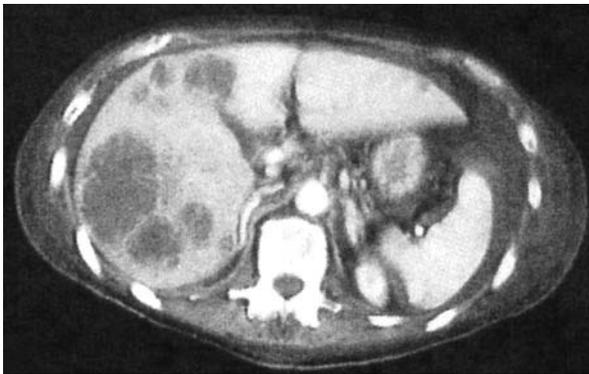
CT scan of the liver lesions reported as multiple liver abscesses
